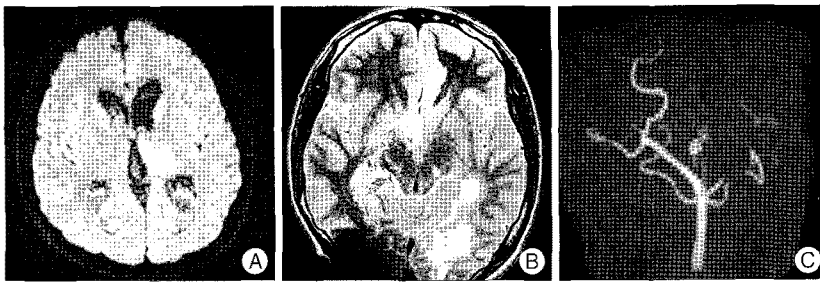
A : Diffusion MRI performed one day after the parent vessel occlusion (PVO) showing acute infarction of the left thalamus and posterior limb of internal capsule. B, C : Old infarction of the left occipital lobe is noted on the T2-weighted image, axial MRI view (B) and occlusion of the PCA beyond the P1 segment is shown on MRA (C) taken 8 months after PVO. PCA : posterior cerebral artery.
